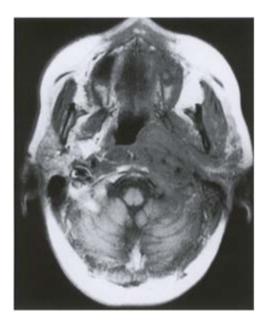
Axial MR image of a space-occupying lesion of the infratemporal fossa which appeared like a tumour, but was caused by an inflammatory process.
